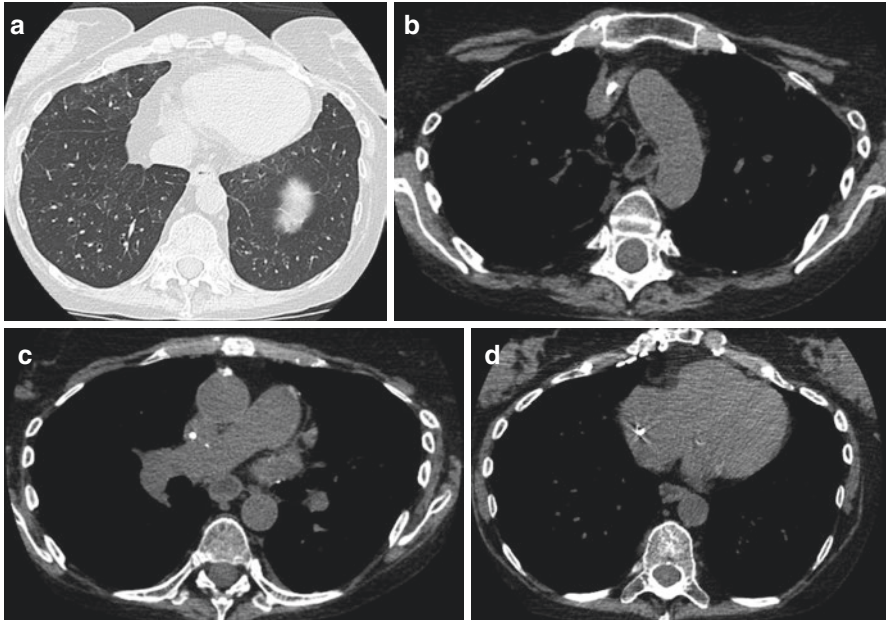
(a–d) A 62-year-old male patient status post DLT with CT evidence of bronchiolitis obliterans (a) and GERD as manifest by a fluid-distended esophagus (b–d). GERD is prevalent in the lung transplant population and is a recognized modifiable risk factor for bronchiolitis obliterans
